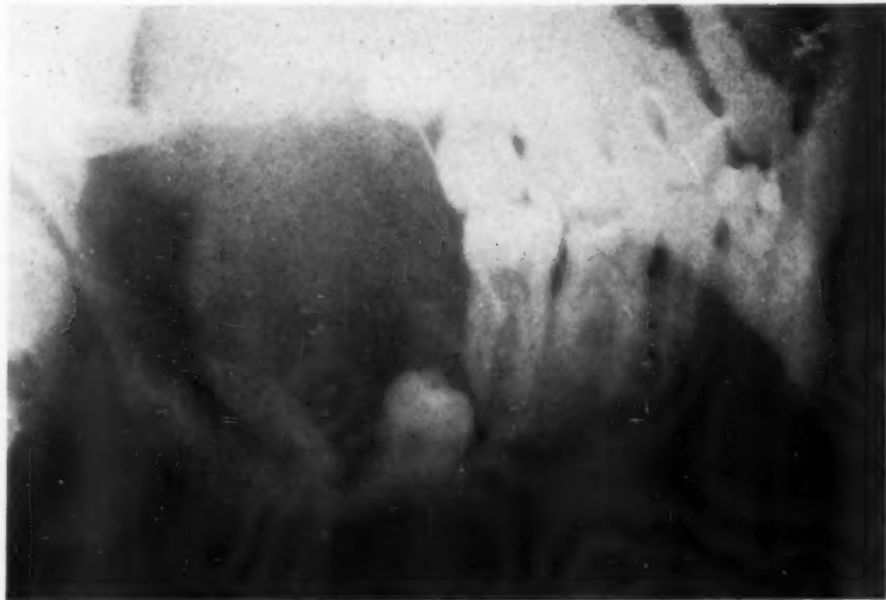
X-ray of dentigerous cyst expanding ramus.
